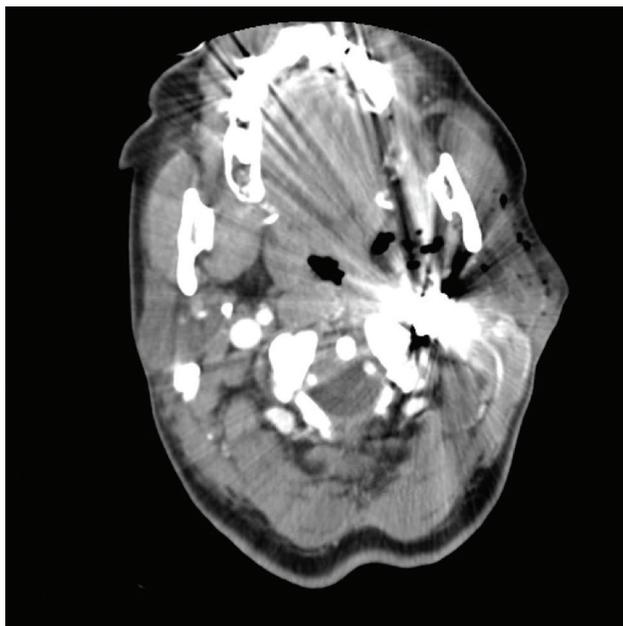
Contrast-enhanced CT (computed tomography) scan images of fragments at the left skull base following penetrating neck trauma.
